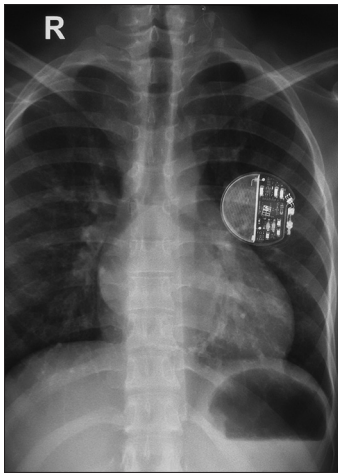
Chest radiograph showing VNS device (VNS= Vagal nerve stimulator)
